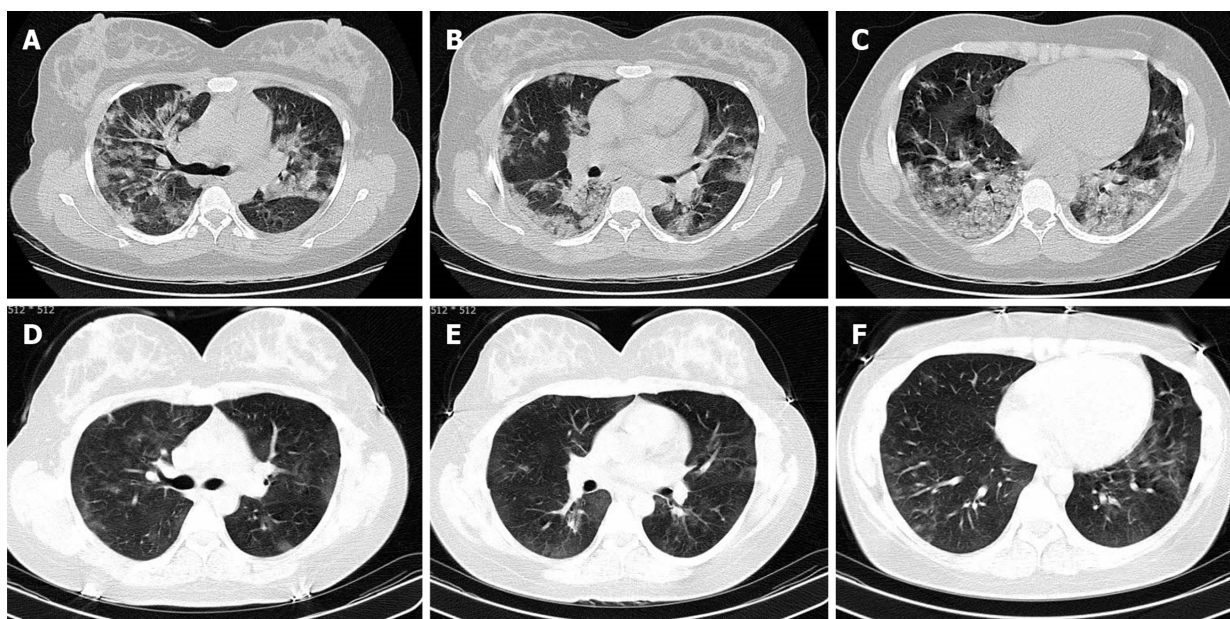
Chest computed tomography scan. A-C: Axial chest computed tomography scan without contrast shows multifocal sub-pleural patchy consolidative opacities in both lung fields compatible with coronavirus disease 2019 pneumonia; D-F: Twelve days later only very faint residual ground glass opacities were seen and the patient's dramatic response to treatment is notable.
